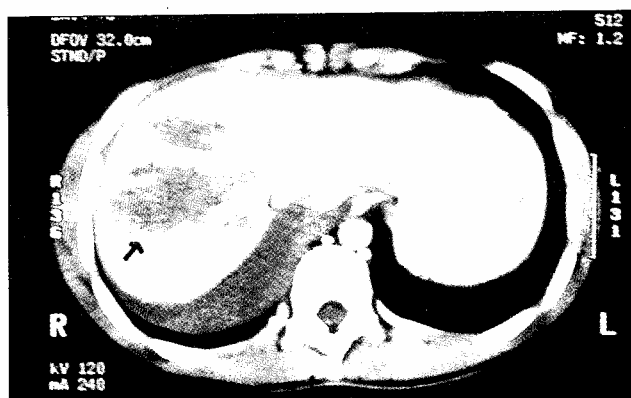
Computed tomogram of the abdomen showing a deep hepatic laceration grade III.
